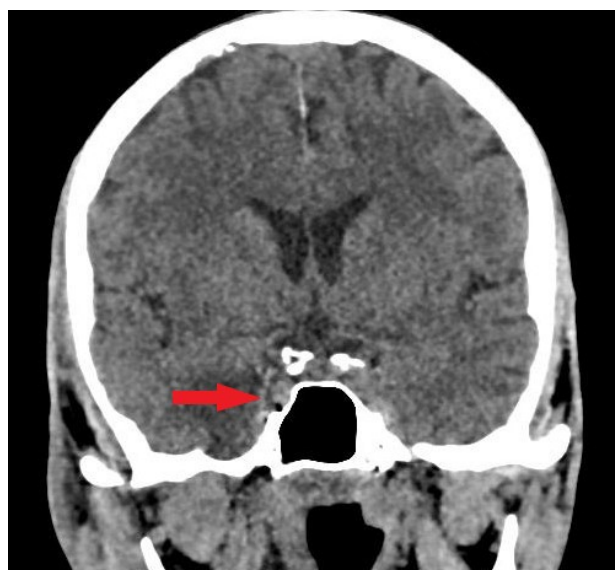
CT of head with amplification in coronal projection. Accumulation of contrast agent in the area of the cavernous sinus on the right
